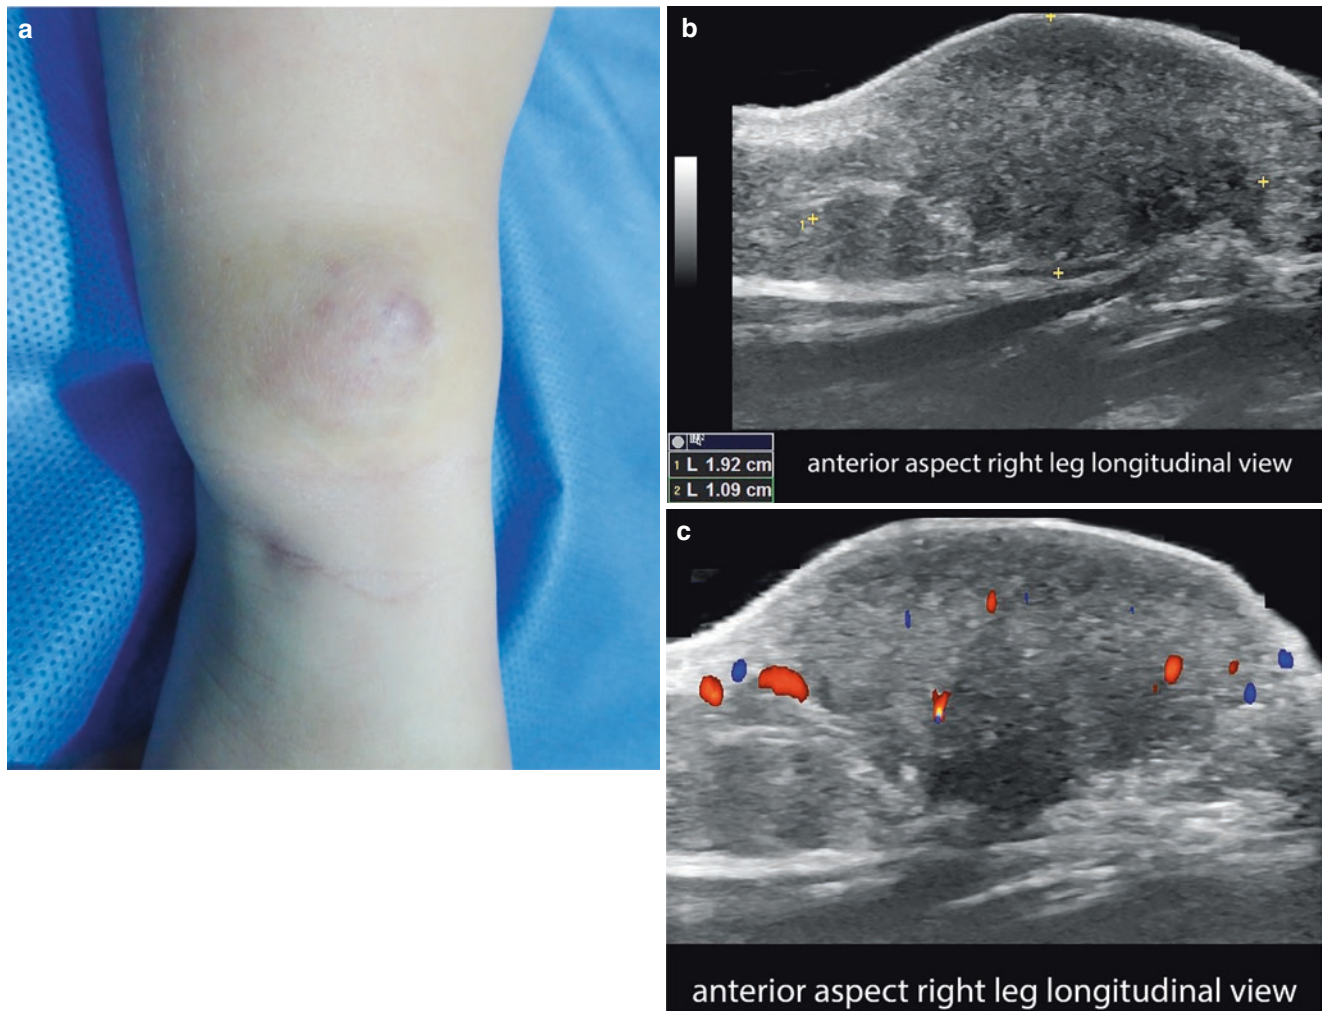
Rapidly involuting congenital hemangioma (RICH). 6-month follow-up of the same case, which has been under observation and without medication. (a) Clinical image (anterior aspect of the distal part of the right leg). (b and c) Greyscale and color Doppler ultrasound (longitudinal views) demonstrates 1.9-cm (long) \times 1.0-cm (thickness)
